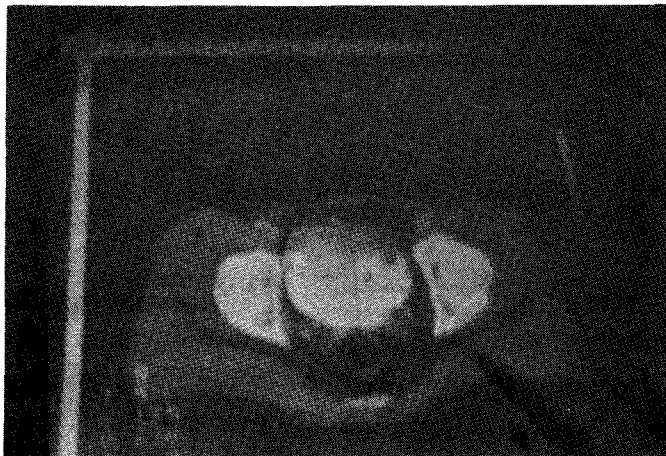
Life size CT image on the graphic table which are to be entered the data with digitizer (▲).
